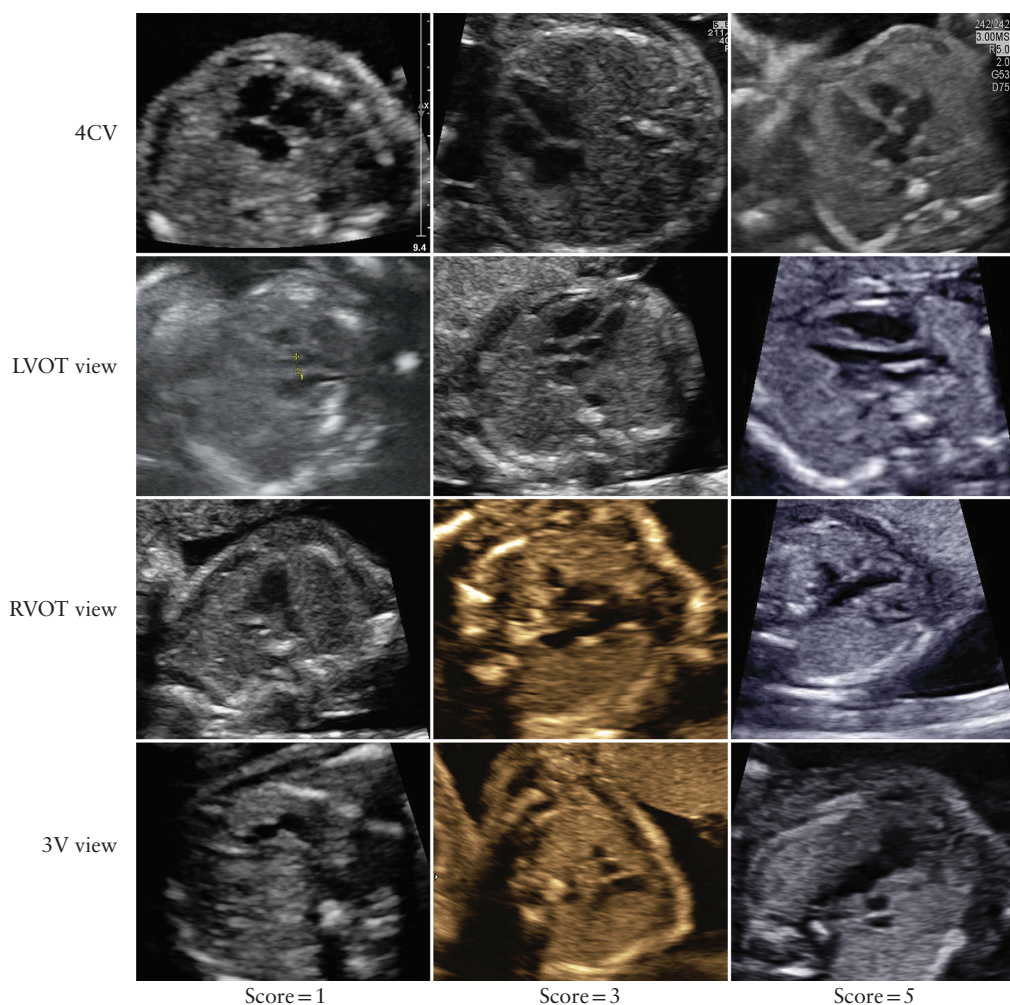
Examples of ultrasound images of fetal heart in four-chamber (4CV), left ventricular outflow tract (LVOT), right ventricular outflow tract (RVOT) and three-vessel (3V) views, that obtained quality score of 1, 3 or 5, in cases with severe congenital heart disease at birth.
